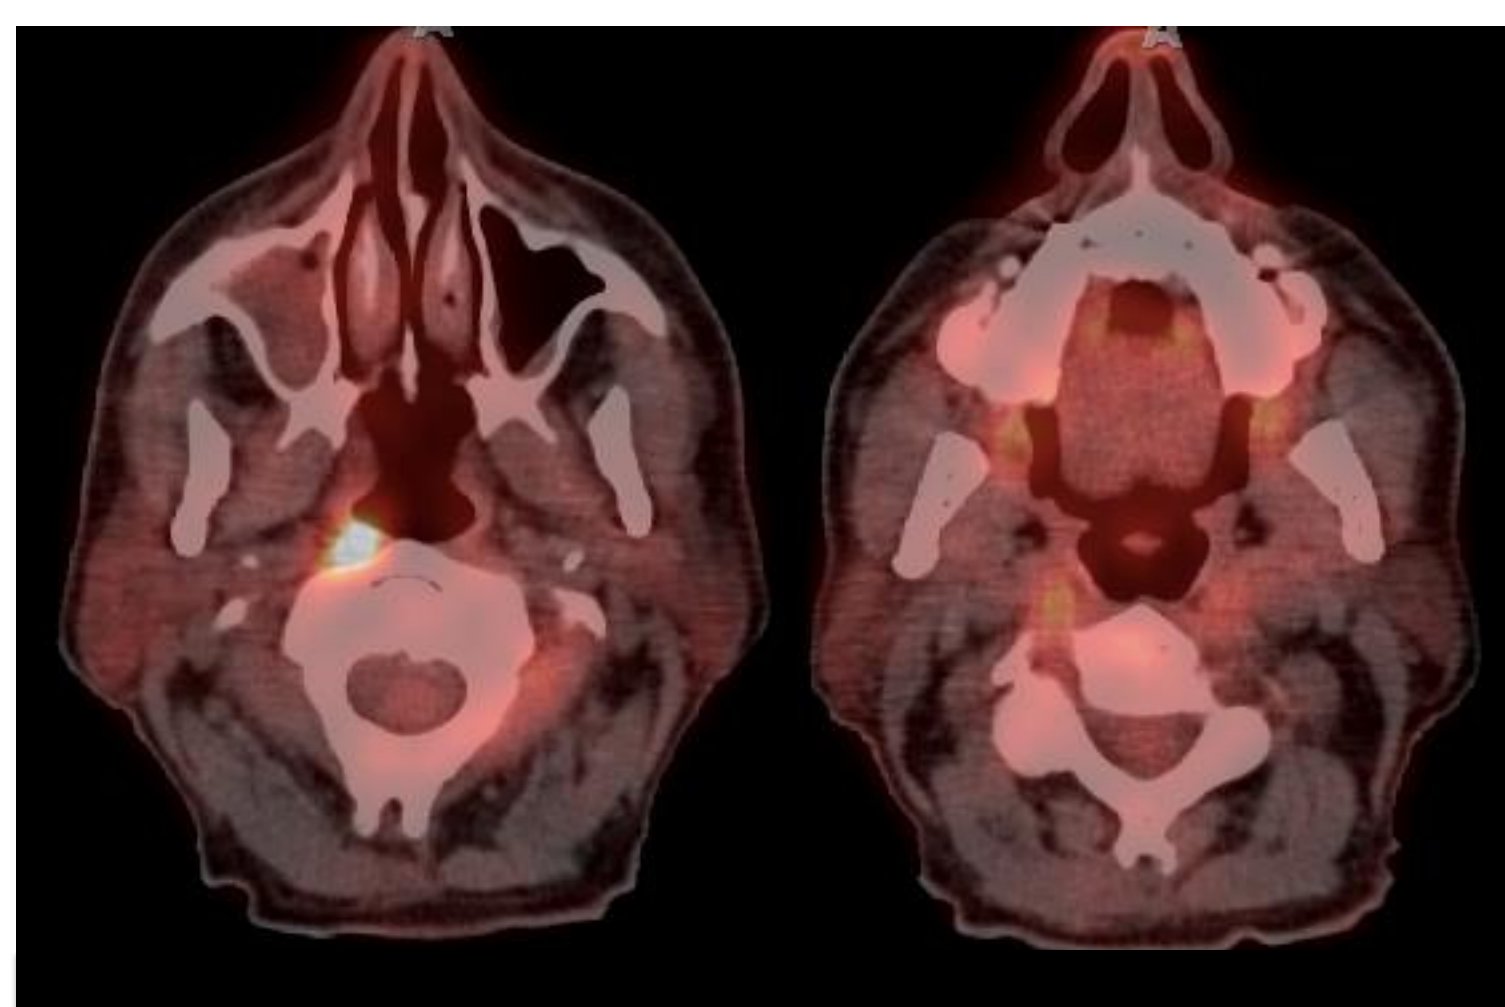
PET CT scan demonstrating deep parotid space and parapharyngeal space of the current patient described following chemotherapy treatment.
